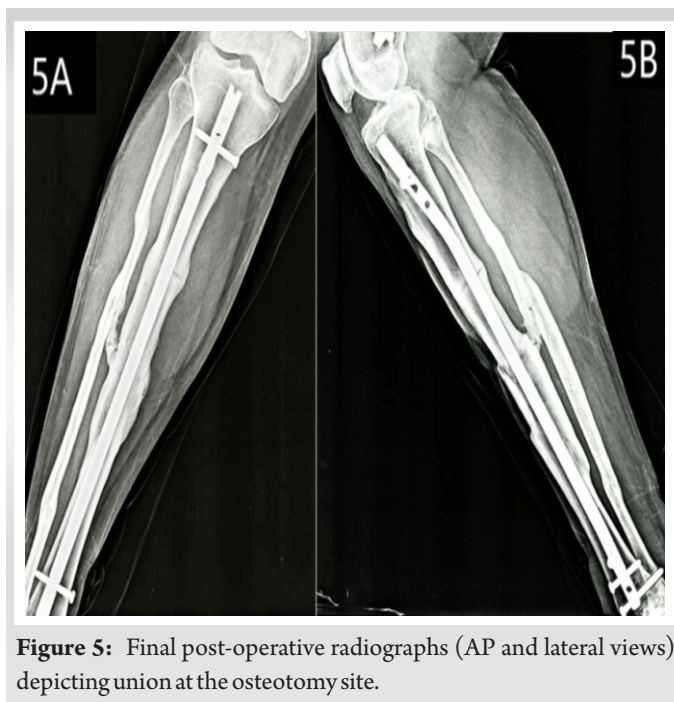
Final post-operative radiographs (AP and lateral views) depicting union at the osteotomy site.
